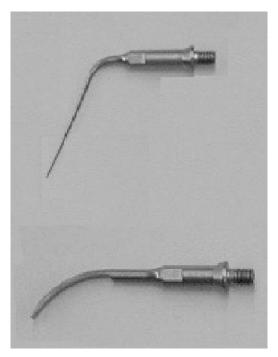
Two tips from the Osada Enac ultrasonic endodontic system. The ST21, shown at the top, is used for removing solids from root canals. The bottom picture shows the vibratory tip ST09.
